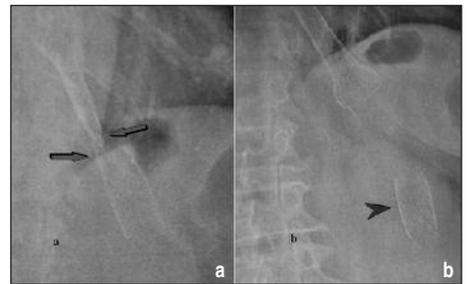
a. Radiograph, eight months after esophageal stent placement. Fracture due to compression of the stent is evident. b. Second stent shown on plain radiograph. Part of first stent distally broken off, falling into the stomach.
